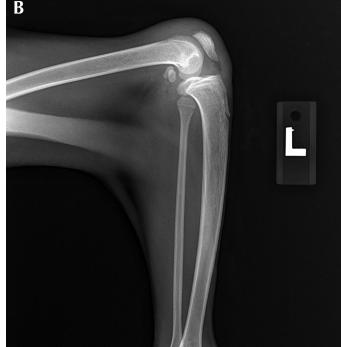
Lateral radiographs of the left and right stifles.
